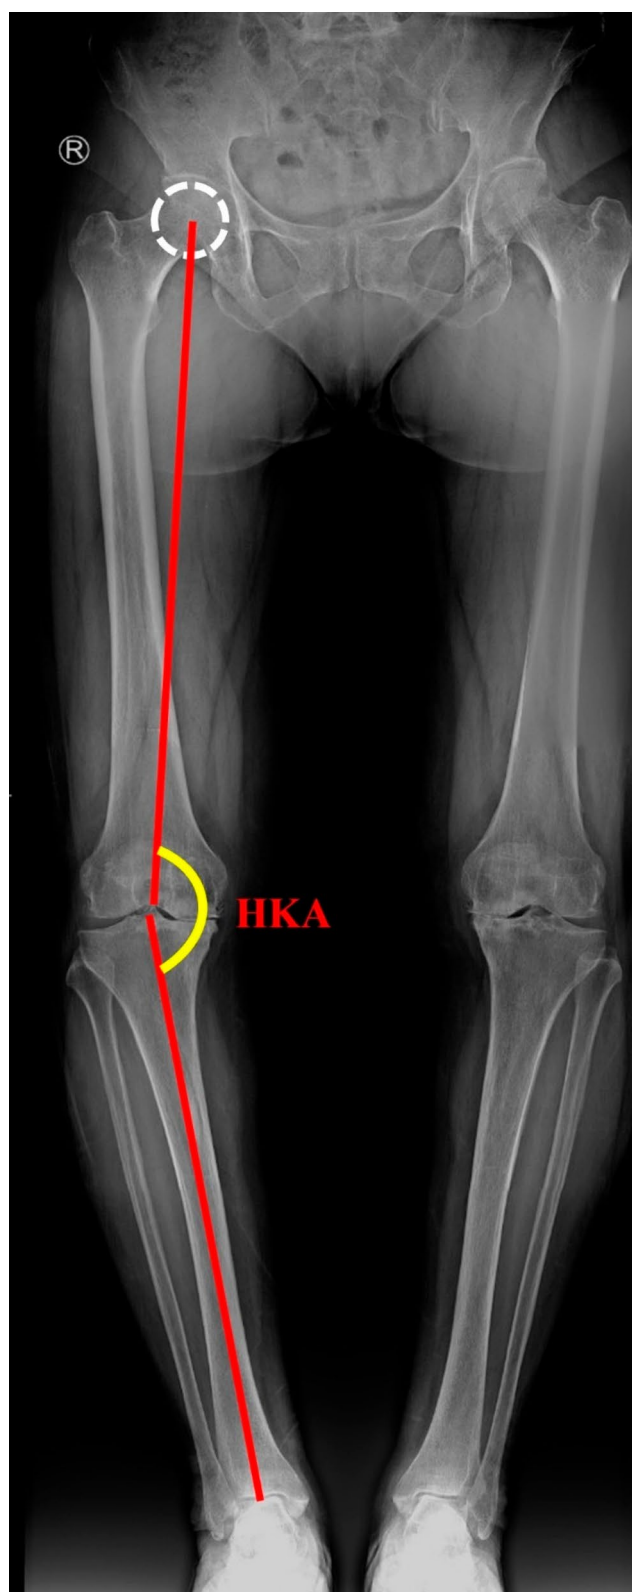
Measurement method of HKA based on preoperative total lower extremity weight-bearing AP radiograph was shown in Fig. 2. HKA was defined as the angle between mechanical axes of femur and tibia. Notably, HKA = 179° means 1° of knee varus in this study
